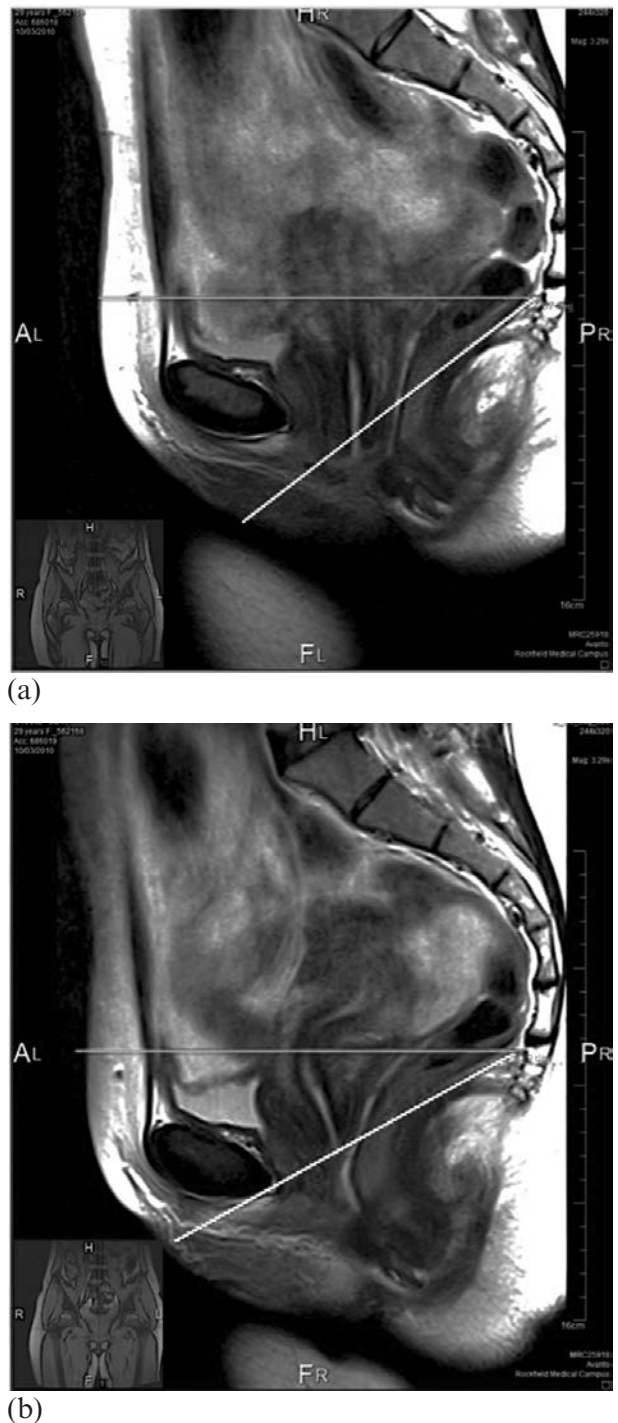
Magnetic resonance imaging scans showing the angle of the levator plate (a) before (37°) and (b) after (29°) manual therapy. Note the elevated position of the uterus following treatment.
